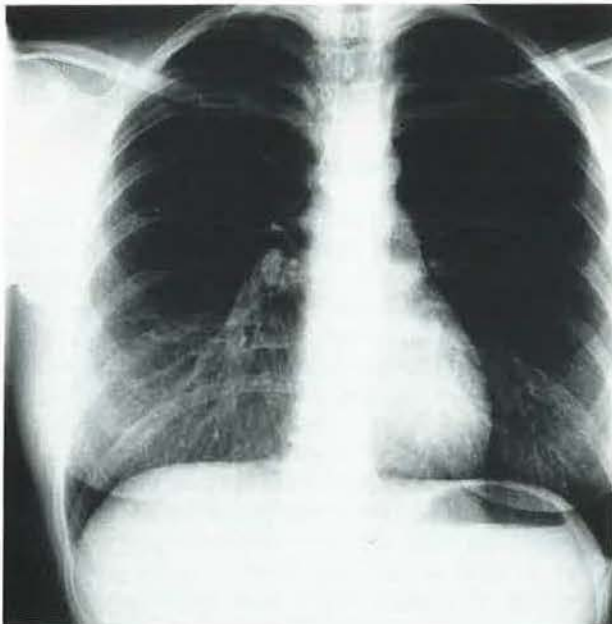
Posteroanterior (PA) roentgenogram.
